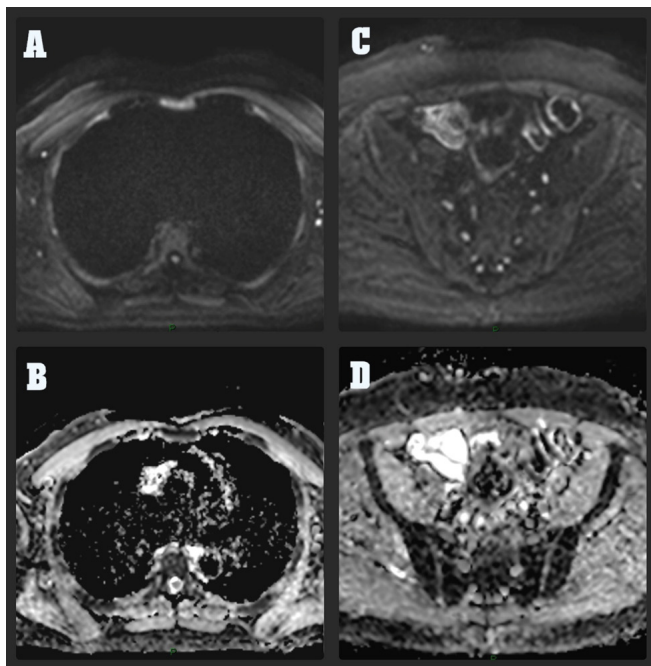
Chest & Pelvis Diffusion-weighted MRI. (A,B) Pelvis DWI & ADC Sequences respectively demonstrates a 10 mm lesion on the right ileum showed hyperintense on high b-value (800) DWI and restricted diffusion on ADC. (C,D) Chest DWI & ADC Sequences respectively, demonstrate a 0.5 cm hyperintense lesion was observed on the posterior portion of the 6th right rib without restriction on ADC.
